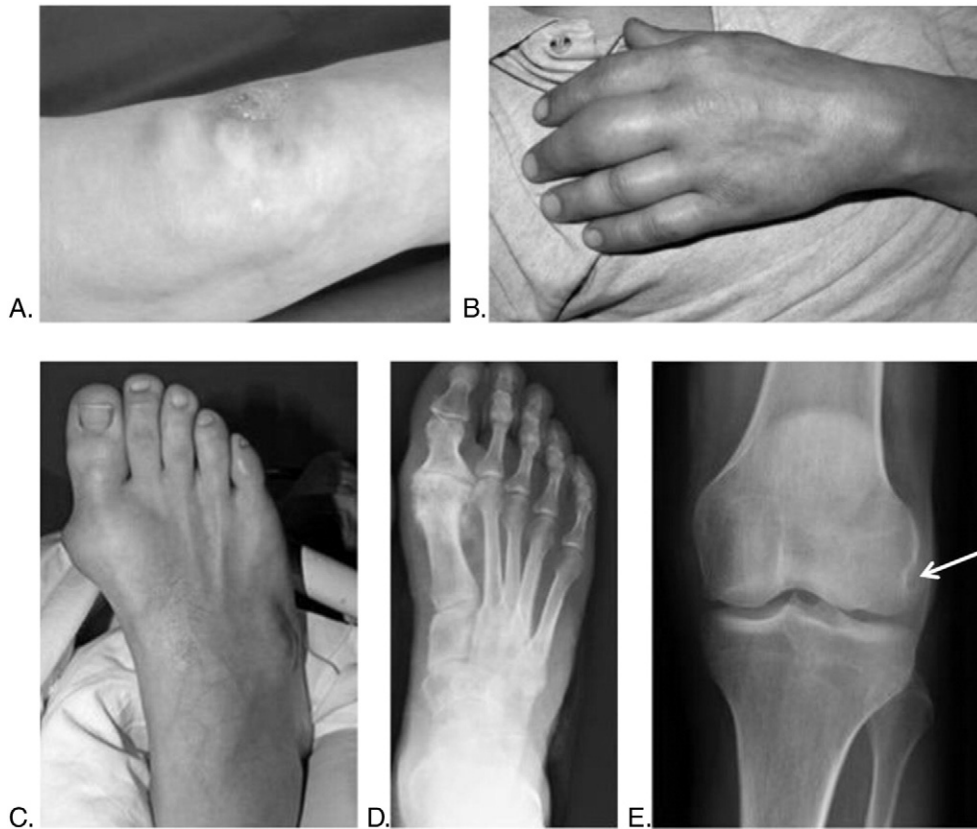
Pictures of a 41-year-old patient with partial HPRT deficiency with chronic tophaceous gout. (A) Tophi on the left knee after spontaneous drainage (February 2016), (B) left hand during acute gouty attack (September 2009), (C) tophi on the right metatarsus (September 2009), (D) radiograph of the foot with the radiographic hallmark findings of chronic gout (February 2016), (E) radiograph of the left knee with a small round radiolucency on the lateral femoral condyle (suspected gouty tophus) (February 2016).
